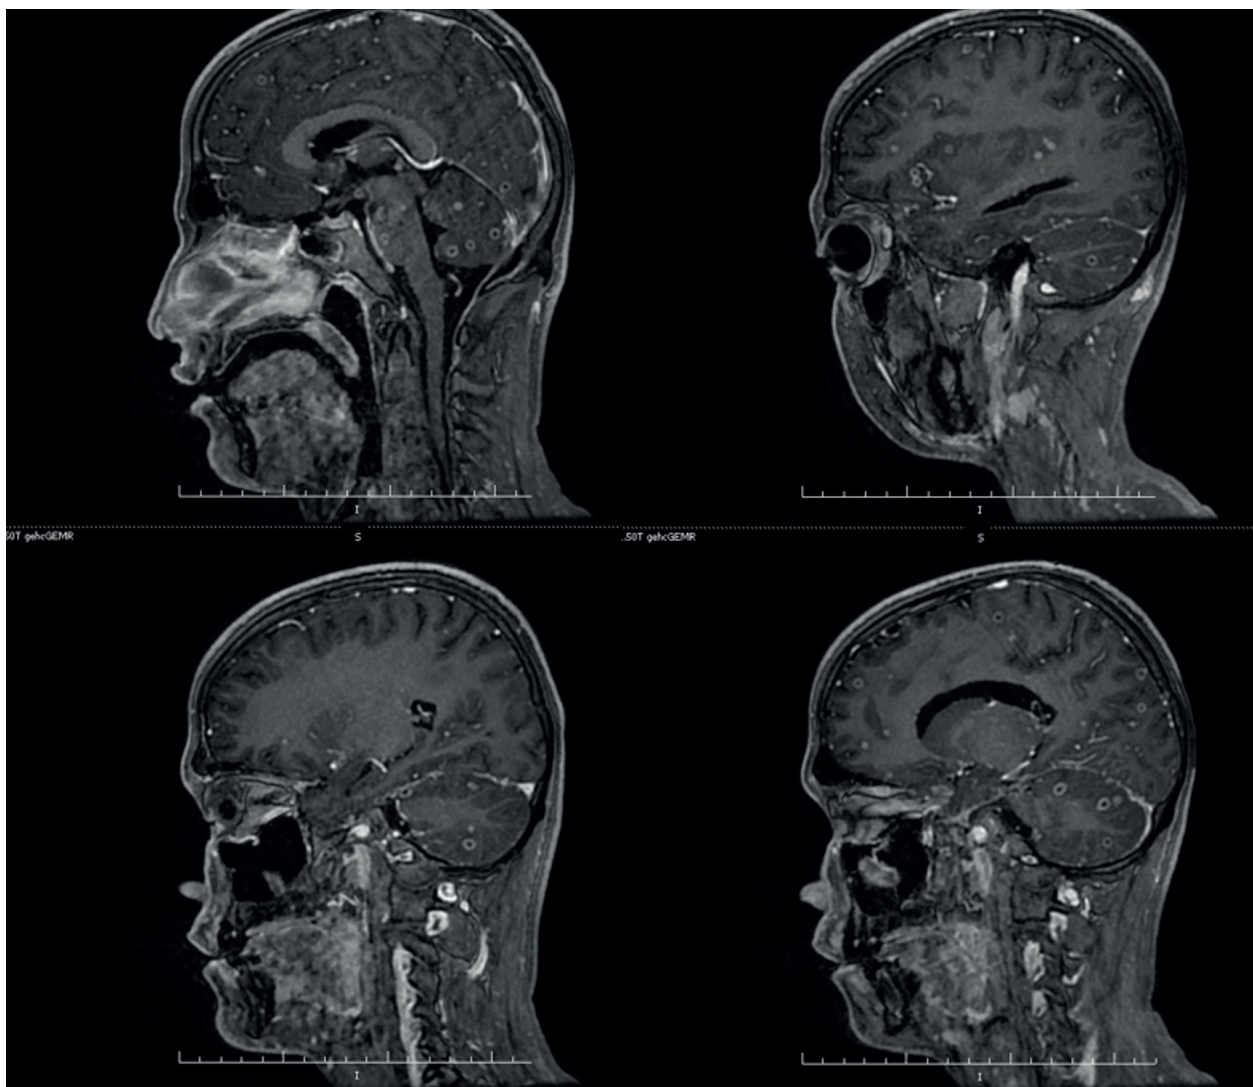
Appearance of tuberculomas from different slices on brain magnetic resonance imaging of the case.
